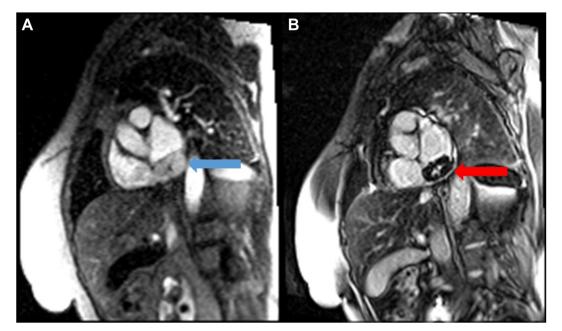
Cardiovascular magnetic resonance imaging sagittal display, basal short-axis view, first-pass perfusion (A) and phase-sensitive inversion-recovery (B) demonstrates an extracardiac, intrapericardial mass with homogenous perfusion sparing a central stellate region (*blue arrow*) and late gadolinium enhancement in the central stellate region (*red arrow*).
